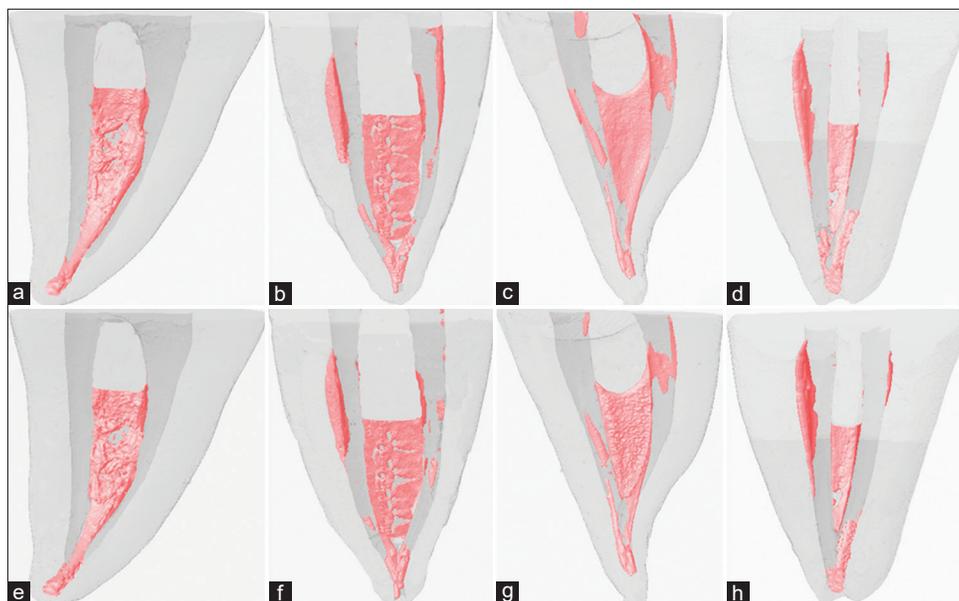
Computed microtomography images of the samples. (a-d) Initial and (e-h) final. (a and e) PUI/AH Plus, (b and f) EC/AH Plus, (c and g) PUI/TF, and (d and h) EC/TF. PUI: Passive ultrasonic irrigation, EC: Easy clean, TF: Total Fill
